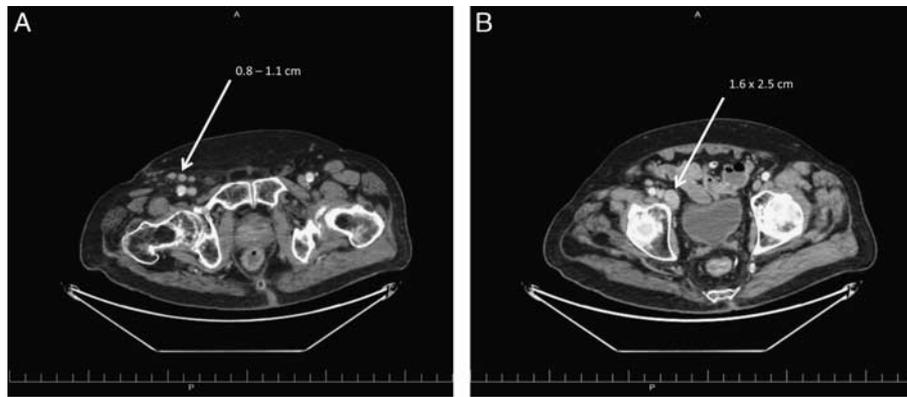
Computed tomographic images of pelvis. Male with right tibial dedifferentiated chondrosarcoma. Biopsy confirmed recurrence ~4 years after initial diagnosis. A, 3 right inguinal lymph nodes (0.8–1.1 cm maximal dimension). B, Right external iliac lymph node (1.6 x 2.5 cm maximal dimension). Arrows indicate the locations of the index lesions within the respective image.
